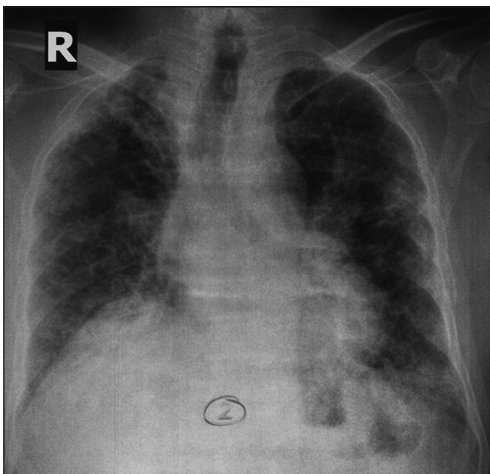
Chest X-ray (posteroanterior view) showing a bilateral reticulonodular pattern with right upper lobe fibrosis
